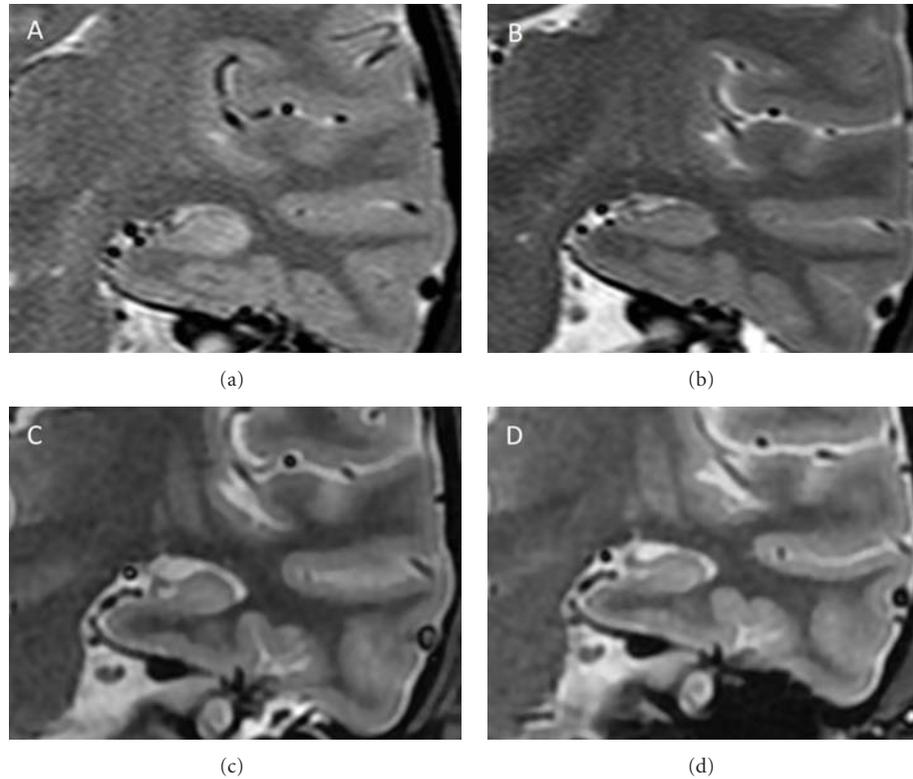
Longitudinal MRI, Coronal T2 (A, B), and fluid inversion recovery (FIR; C, D) images are shown through the hippocampus for the patient described in case number 2. While the initial imaging for this patient was normal (not shown), the hippocampus appears bright and somewhat edematous 10 days after the onset of status epilepticus (A). Thirty days after the onset of refractory status epilepticus (B), the edema has resolved, and the hippocampus appears atrophic. At 2 (C) and 6 (D) months after the onset of status epilepticus, progressive hippocampal atrophy is noted.
